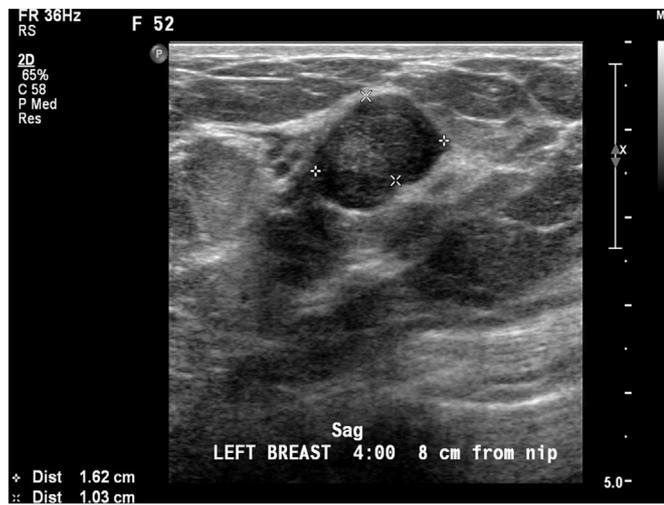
52 year old women presented with a palpable mass showing a well circumscribed, oval, lobulated hypoechoic mass, measuring 2.2 × 1 × 1.6 cms. Ultrasound guided core biopsy showed a “Fibroadenoma”. Subsequently three years later the patient presented with enlargement of the biopsy proven fibroadenoma. Ultrasound showed the mass to now measure 2.9 × 2.5 × 2.5 cms. Ultrasound guided core biopsy subsequently showed “Fibroepithelial lesion with increased stromal cellularity” and excision was recommended. Surgical excision showed a “Benign phyllodes tumor”.
